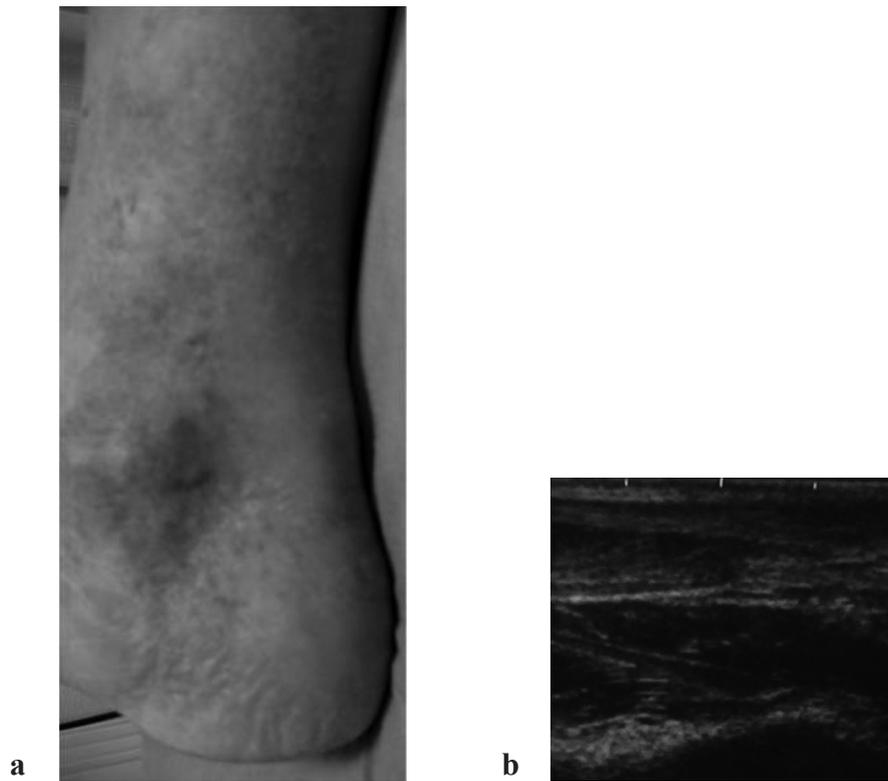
A) Achilles tendon with degenerative fibres and nodular thickening in mid body tendon. B) Ultrasound exam of Achilles tendon with degenerative fibres and nodular thickening in mid body tendon*
